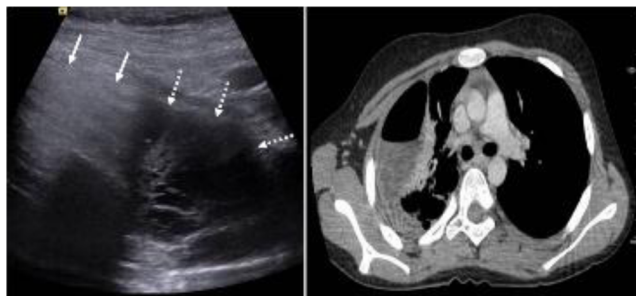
US revealed the presence of air (arrows) and multiseptated pleural effusion (dotted arrows) within the pleural space (left image). CT showed a classic pattern of hidropneumothorax, without detection of septa within pleural space (right image).
